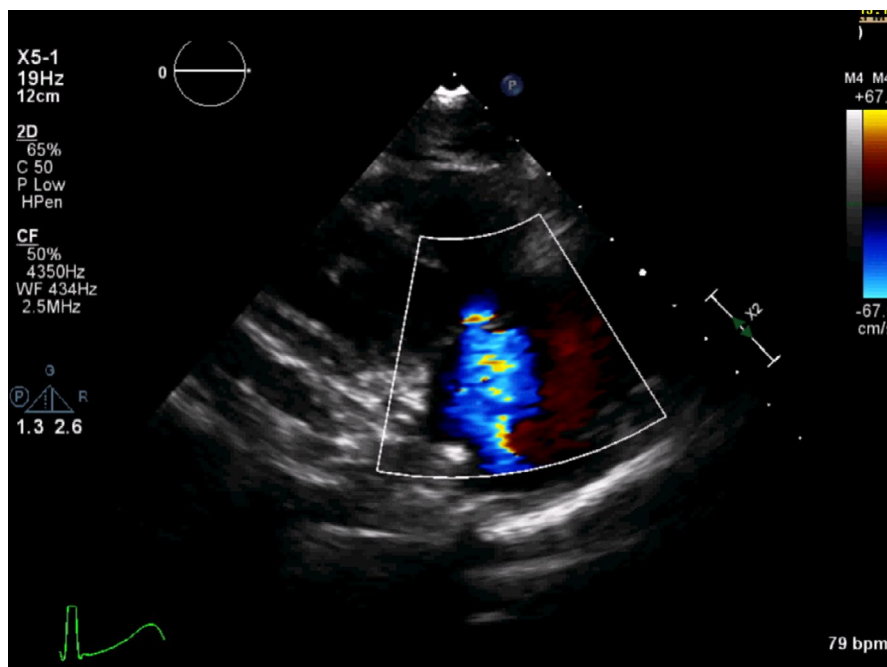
Parasternal long-axis image with posterior angulation showing the tricuspid valve with moderate regurgitation at initial presentation
